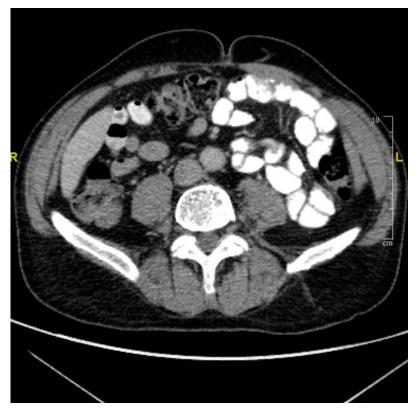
CT Scan January 2022 shows no free fluid and no lesions. No abnormalities found in soft tissues or abdominal wall.
